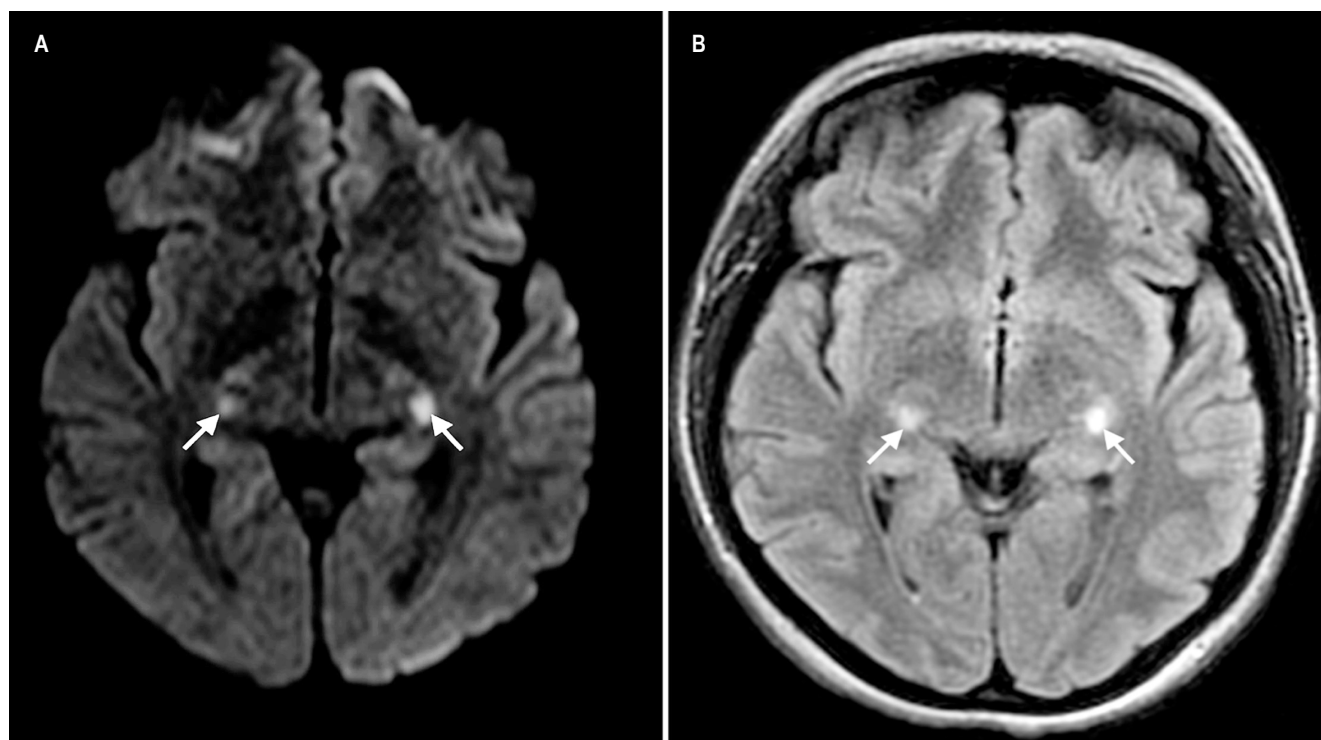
Brain MRI Findings. A. Diffusion-weighted imaging (DWI) showing signal enhancement in the lateral geniculate bodies, predominantly on the left side (arrows). B. FLAIR images with hyperintensities in the same distribution. Author's File.
